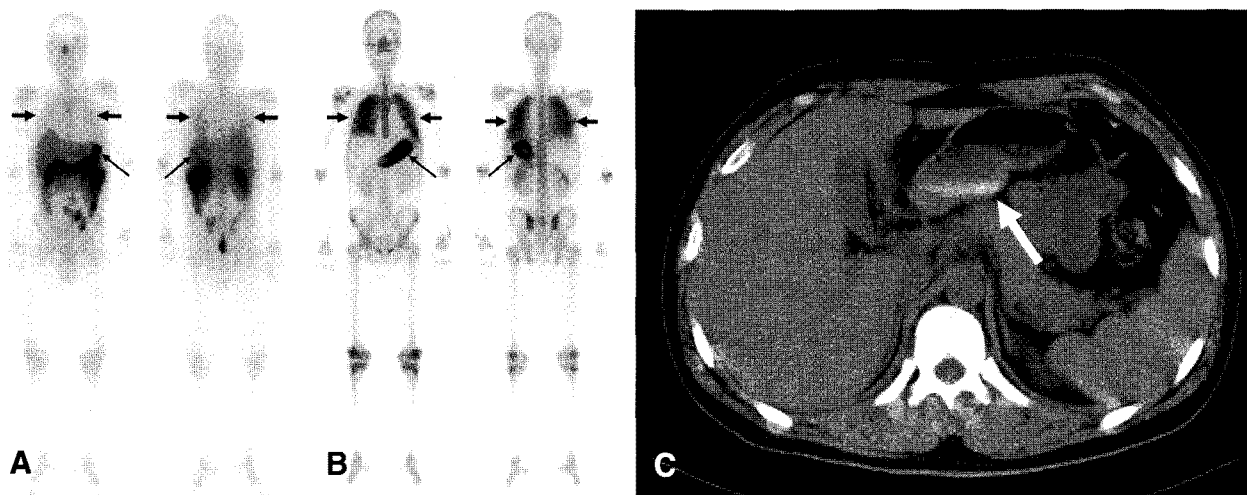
A 26-year-old man presented with a 2-week history of lethargy, fever, and weakness in both lower legs. The laboratory findings showed anemia and acute renal failure with hypercalcemia (total calcium, 18.1 mg/dl; normal range, 8.4~10.2 mg/dl). The phosphate level (6.3 mg/dl; normal range, 2.5~4.5 mg/dl) was also elevated. The parathyroid hormone (0.01 pg/ml; normal range, 11~62 pg/ml) and 1,25(OH)₂ vitamin D₃ levels (3.1 ng/ml; normal range, 10~55 ng/ml) were decreased. Parathyroid hormone-related protein (PTHrP) was elevated (31.2 pmol/l; normal range, <1.3 pmol/l). Results of a subsequent bone marrow examination revealed a primitive neuroectodermal tumor. (A) Anterior and posterior whole body scintigraphy images performed 48 hours after injection of 185 MBq (5 mCi) Ga-67 showed abnormally increased uptake in the lung (thick arrows) and stomach (thin arrows). Three days later, a Tc-99m MDP bone scintigraphy was performed. (B) Anterior and posterior whole body images demonstrated increased uptake in the same sites as those revealed by the Ga-67 scintigraphy. The findings on bone scintigraphy were consistent with metastatic calcifications. Although a plain radiograph and CT of the chest showed no abnormalities, (C) a CT of the abdomen demonstrated calcification in the gastric wall (arrow).
